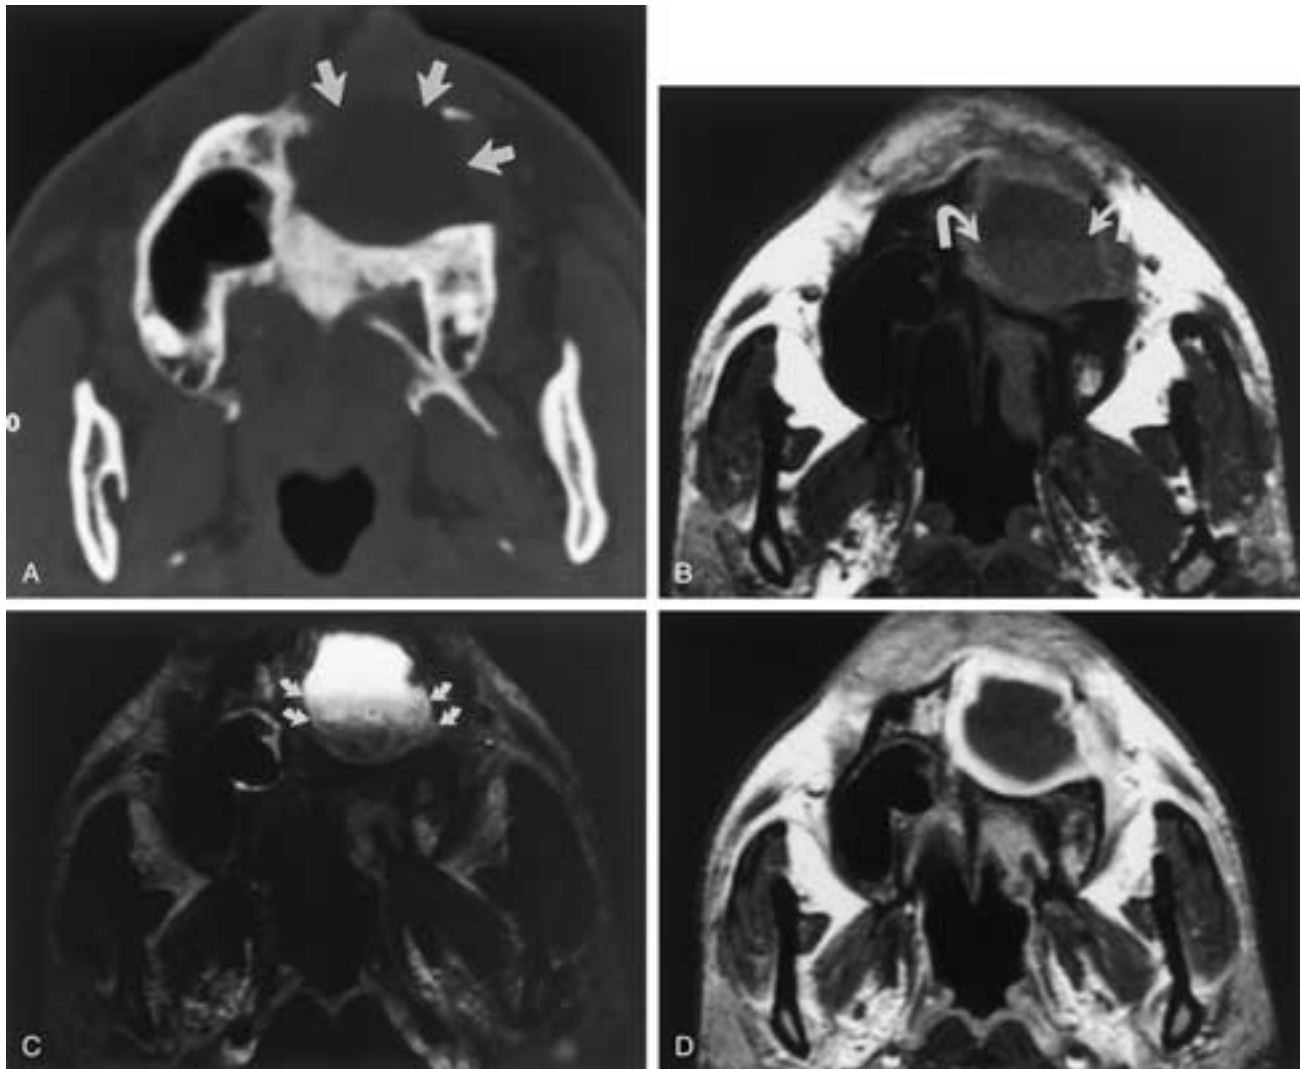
Schwannoma in a patient with neurofibromatosis type 2 (probably of the incisive canal). A, Axial CT scan at a bone window setting demonstrates a cystic-appearing mass that has destroyed much of the left hard palate and portions of the left maxillary alveolus (*arrows*). Axial T1-weighted (B) and T2-weighted (C) MR images confirm the cystic nature of this lesion and demonstrate a fluid level within it (*arrows*). The T2-weighted image (C) actually shows three definite different density levels. Following contrast administration, an axial (D) image reveals well-defined rim enhancement.
